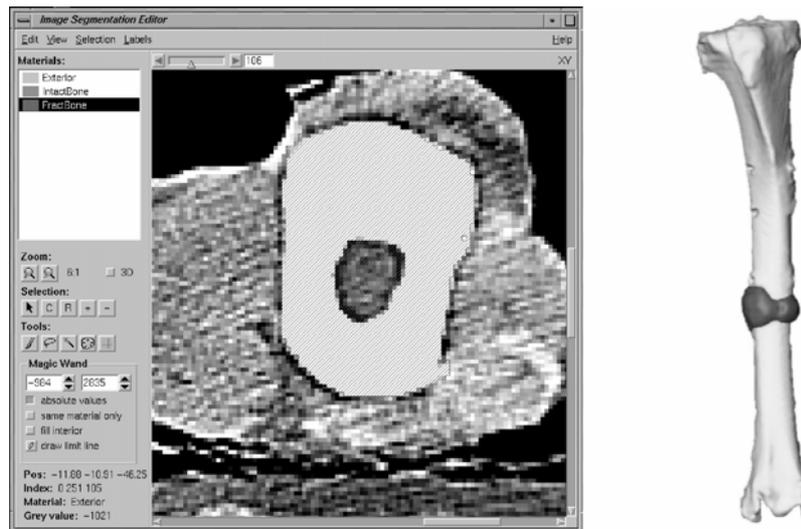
(left) screenshot from Amira program showing segmentation of mineralised tissue (right) tibia reconstructed from CT data showing callus formation (dark grey) at 6 weeks
